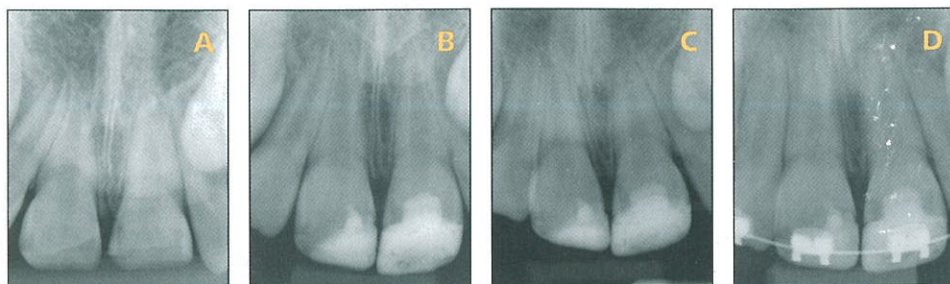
(A) Preoperative periapical radiograph of teeth #8 and #9 with pulp exposures. (B) Postoperative radiograph taken after the partial pulpotomy procedures using MTA as pulp capping material. (C) Six-month follow-up periapical radiograph showing continued tooth development. (D) Eighteen-month follow-up periapical radiograph showing normal tooth development and the absence of periradicular pathosis. Photos courtesy of Dr. R. Schwartz, San Antonio, Texas.
